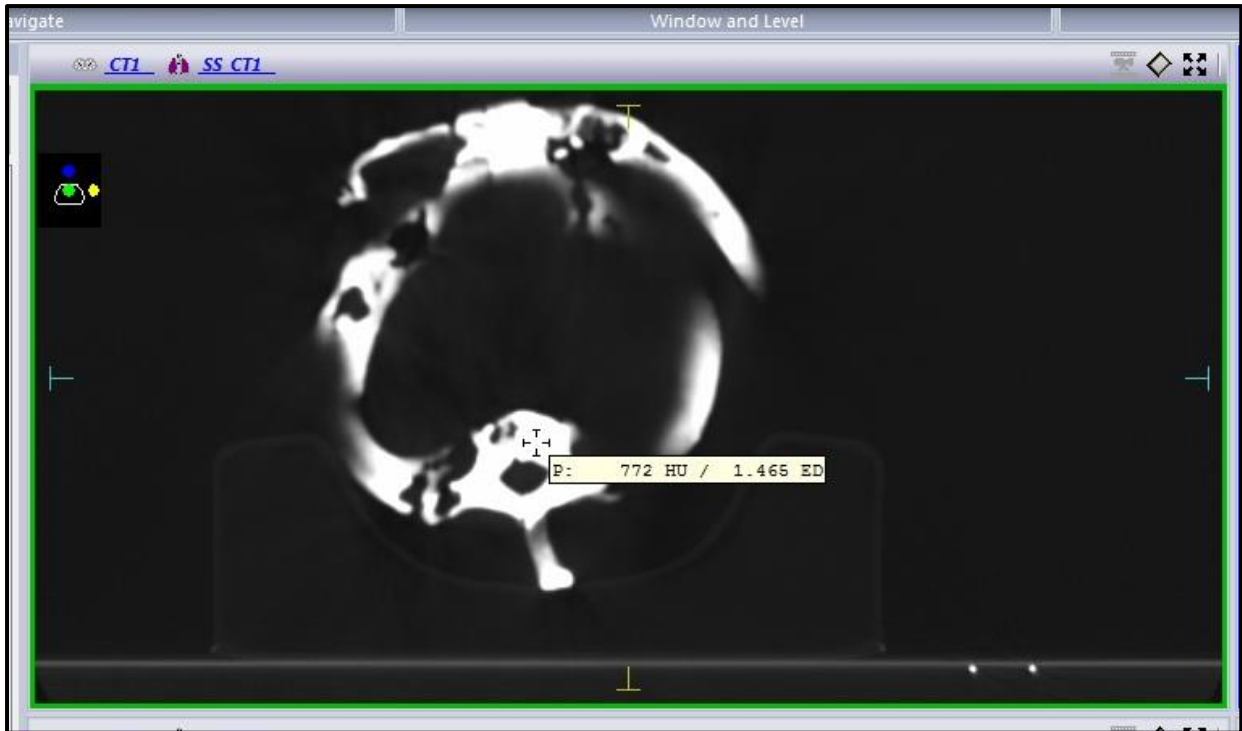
CT scan of reprint of section of ribcage
